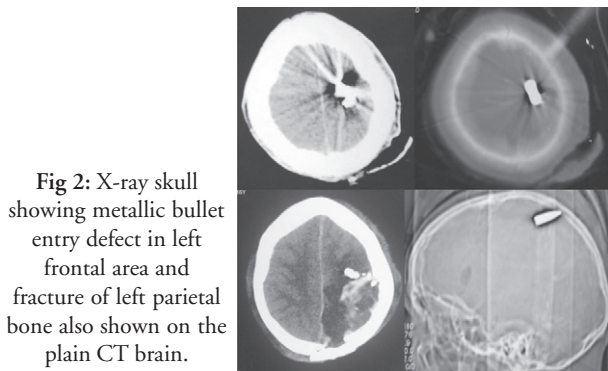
X-ray skull showing metallic bullet entry defect in left frontal area and fracture of left parietal bone also shown on the plain CT brain.
